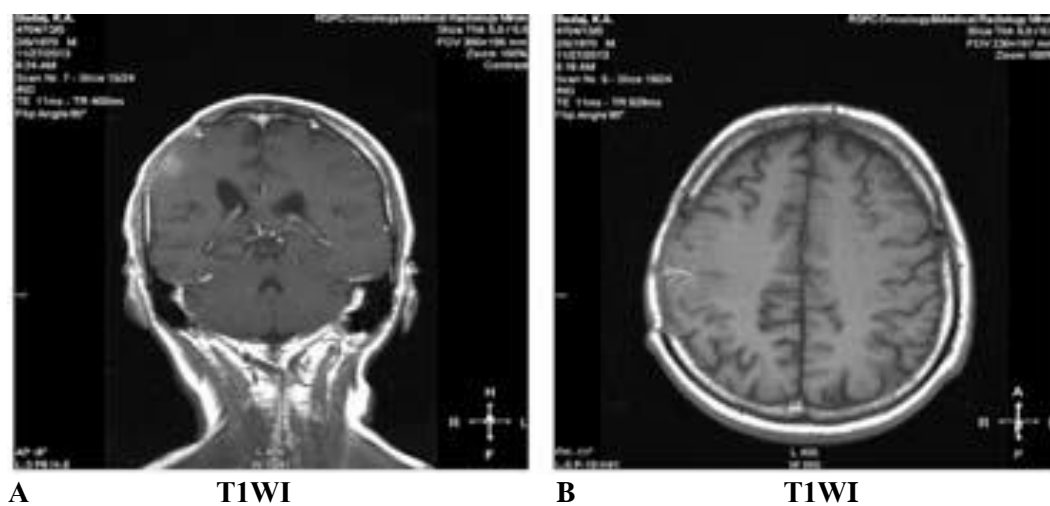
MRI of patient B., 43 years old. A – T1WI, frontal projection mode. B – T1WI, axial projection 6 months after the surgery
